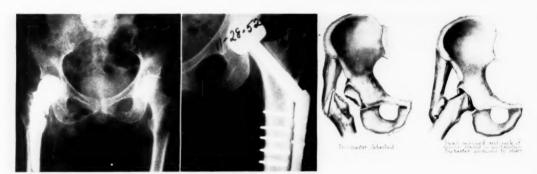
Roentgenogram showing Judet prosthesis in situ. Before and after operation.
